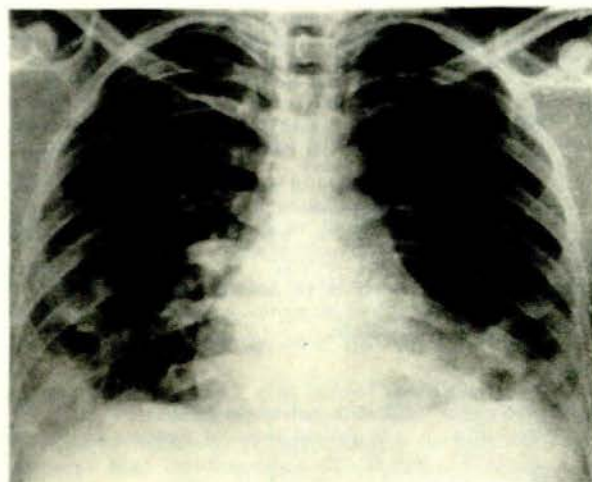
X-ray of the chest showing numerous cavities in both lung fields.
